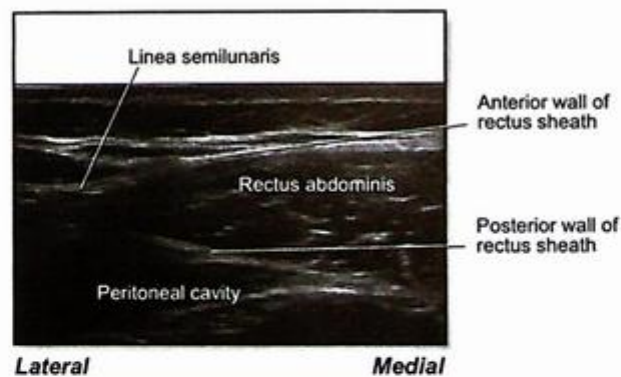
An ultrasound image showing an ideal view to perform a successful block.
